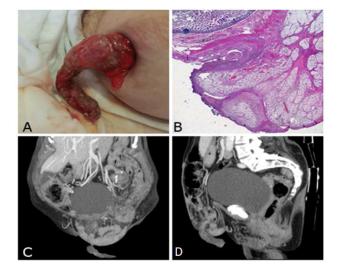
A: Ectoscopic aspect of the abdominal wall showing the exit of abdominal contents through cutaneous dehiscence. B: Adipose tissue from omentum with a fibro inflammatory reaction and presence of foreign body granulomatous reaction. C and D: Abdominal CT study. Sagittal and coronal reconstruction in which abdominal eventration
